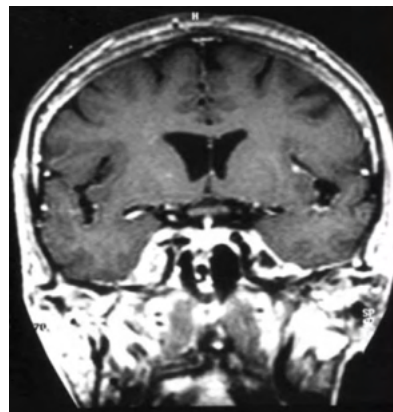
MRI showing T1 hypointense lesion in the right cavernous sinus.
